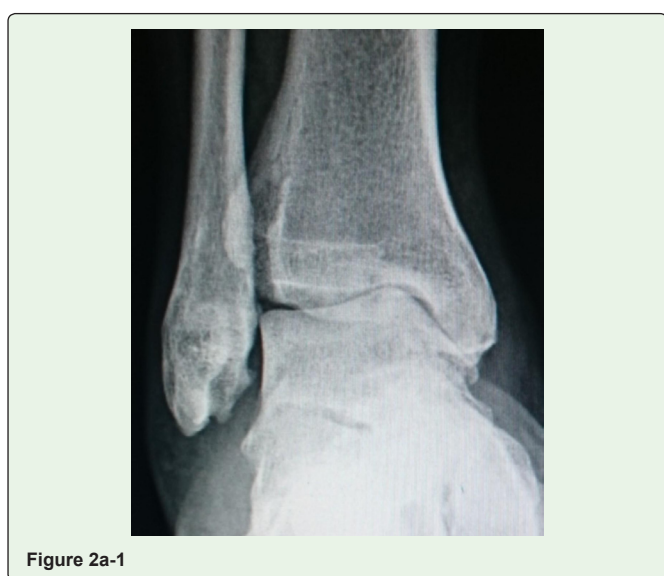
A 61-year-old man with varus-type ankle osteoarthritis. 2a: Preoperative findings. 1) X-ray classification was Stage 3b. 2)-4) arthroscopic grade was 3.
